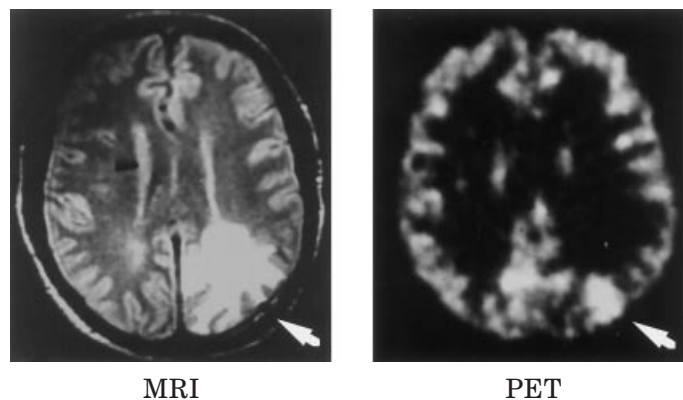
Comparison between MRI spin echo and PET glucose metabolism of a brain tumor. MRI shows increased water and longer T_2 relaxation in and around (edema) the tumor. PET shows increase in glucose metabolism typical of brain tumors. Detection of probable islands of tumors outside the bright spot (arrow) depends on the resolution of the PET scanner.
